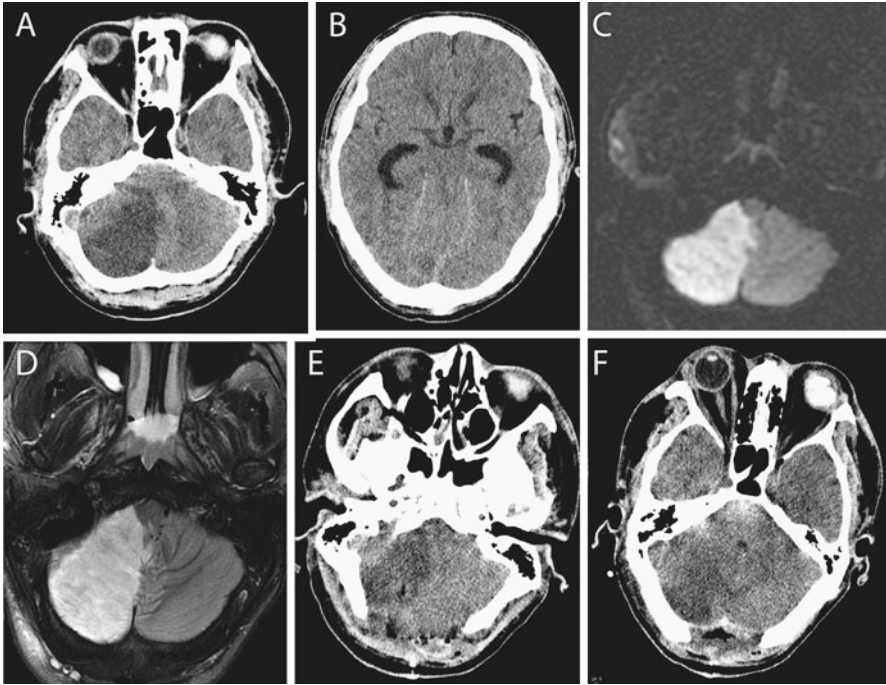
Cerebellar stroke may lead to edema and obstructive hydrocephalus. This 27-year-old man with a history of an intracardiac arteriovenous shunt presented with a 4-h history of headache, nausea, and vomiting and decreased level of consciousness. He presented in extremis with bilateral fixed pupils and no motor response. (a, b) A posterior inferior cerebellar artery infarct was diagnosed with complete obliteration of the fourth ventricle (a) and acute hydrocephalus (b). (c, d) An emergent extraventricular drain was inserted followed by magnetic resonance imaging (MRI) diffusion-weighted imaging (c) and T2 imaging (d) that confirmed a completed stroke as hyperintensity in the vascular distribution. (e, f) The patient was taken for posterior fossa decompression and expansion duroplasty. Edematous, infarcted tissue was resected from the cerebellum during the procedure to facilitate closure. The fourth ventricle was patent after the case (f). The patient went on to make a full neurological recovery
